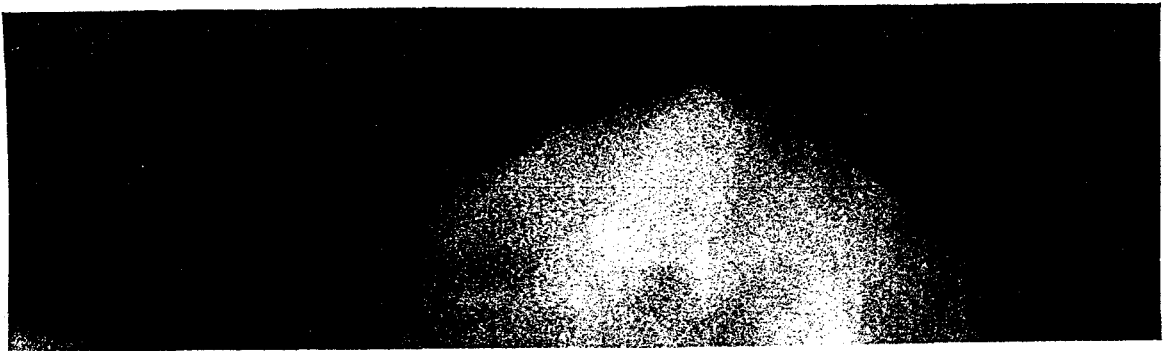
(a) Left side breast, x-ray image.
